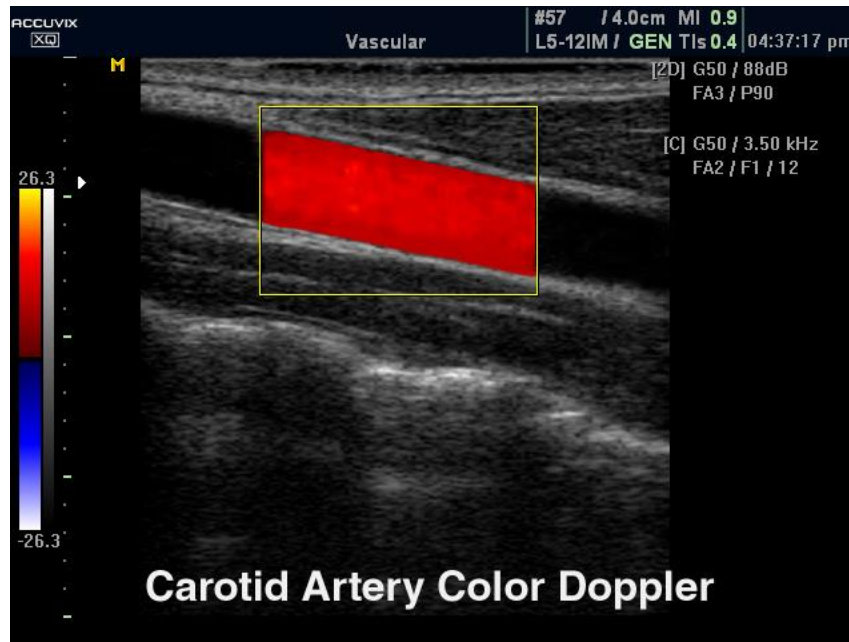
Figure A-1: Carotid Artery Color Doppler (Source: medison.ru)
